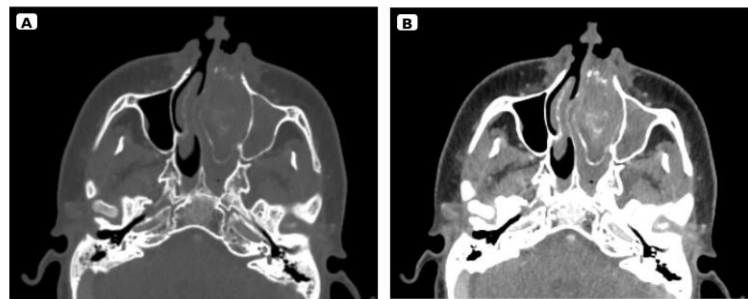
CT findings of the left sinonasal lesion. A) Axial non-contrast bone-window image shows an expansile lesion centered in the left nasal cavity with internal spontaneous hyperdense foci. B) Axial contrast-enhanced image shows no significant internal enhancement and associated ipsilateral maxillary extension
